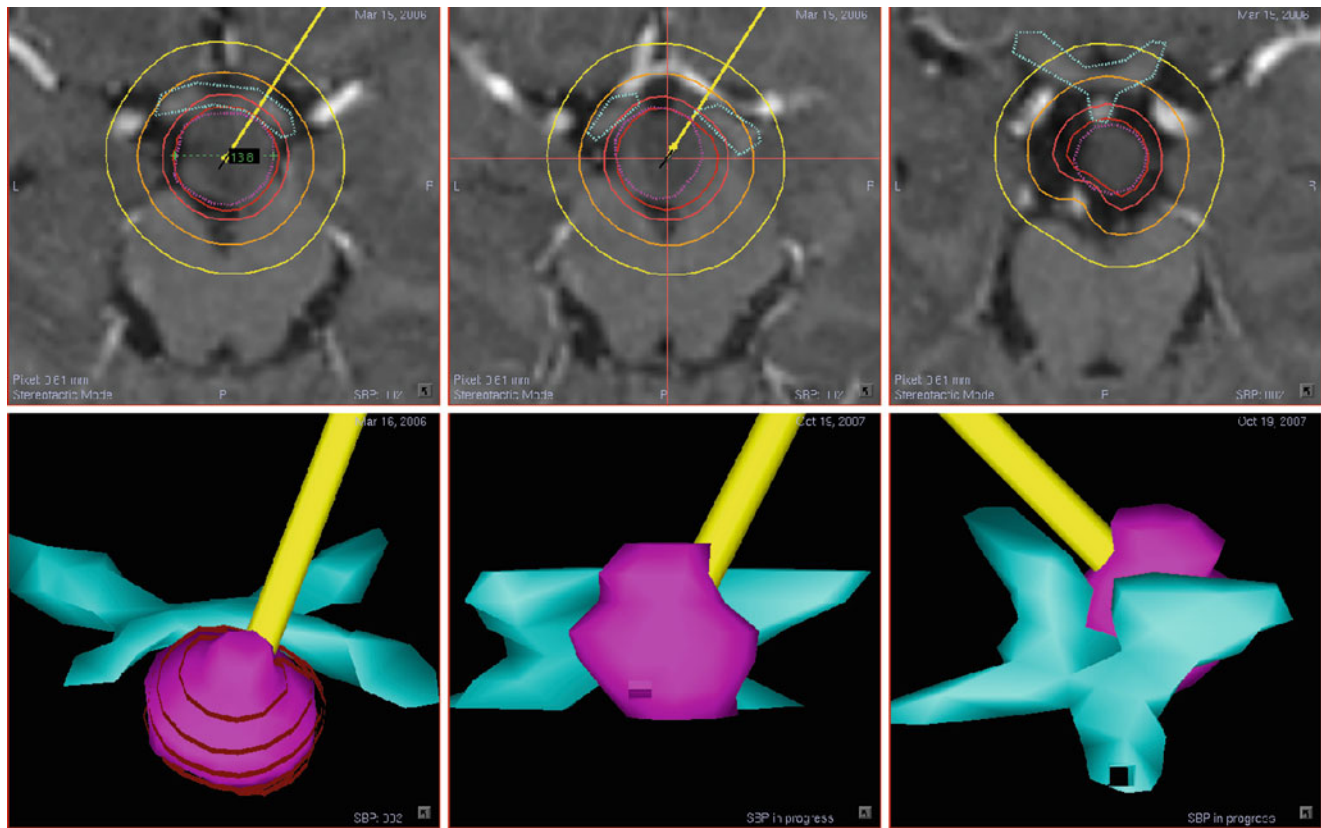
The treatment plan for a stereotactic biopsy with subsequent implantation of an Iodine-125 seed in a patient with a hypothalamic hamartoma suffering from long-term pharmacoresistant gelastic epilepsy is shown. The *upper line* gives three horizontal MRI views; in the *lower*
